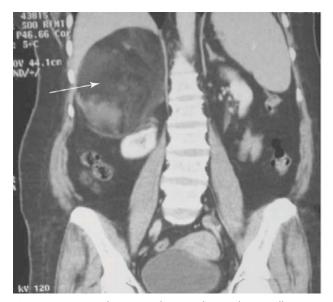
Computed tomography scan shows a large well-circumscribed fat density mass with internal areas of hemorrhage (White Arrow).
